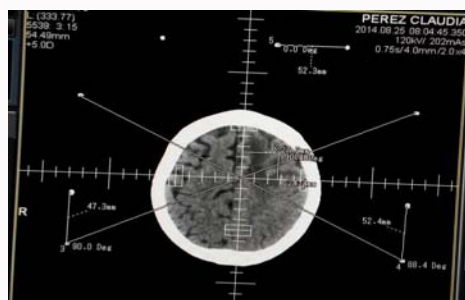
Pre-biopsy brain CT.
